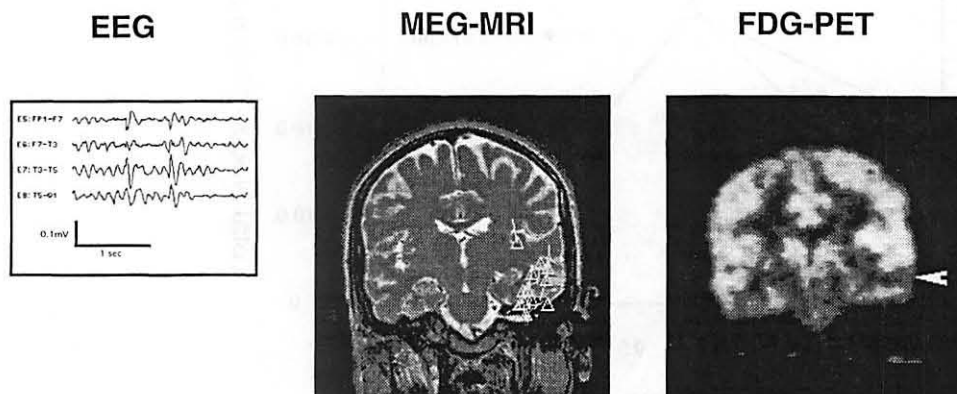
Left: scalp EEG recording of patient's epileptiform spike activity recorded over the left temporal region; middle: T2 weighted coronal MRI slice with dipole sources (triangles), which correspond to EEG spikes, localized adjacent to a focal area of increased T2 in the left middle temporal gyrus; right: coregistered FDG-PET slice reveals focal relative hypometabolism (white arrow) in the same region of the left middle temporal gyrus (Data courtesy, Departments of Radiology and Neurology, UCSF).
